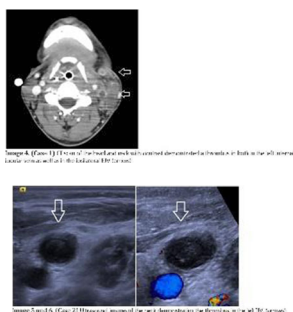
(Case 1) CT scan of the neck showing central demyelinated area in both the left and right internal carotid arteries (arrow). (Reprinted with permission from [10].)
